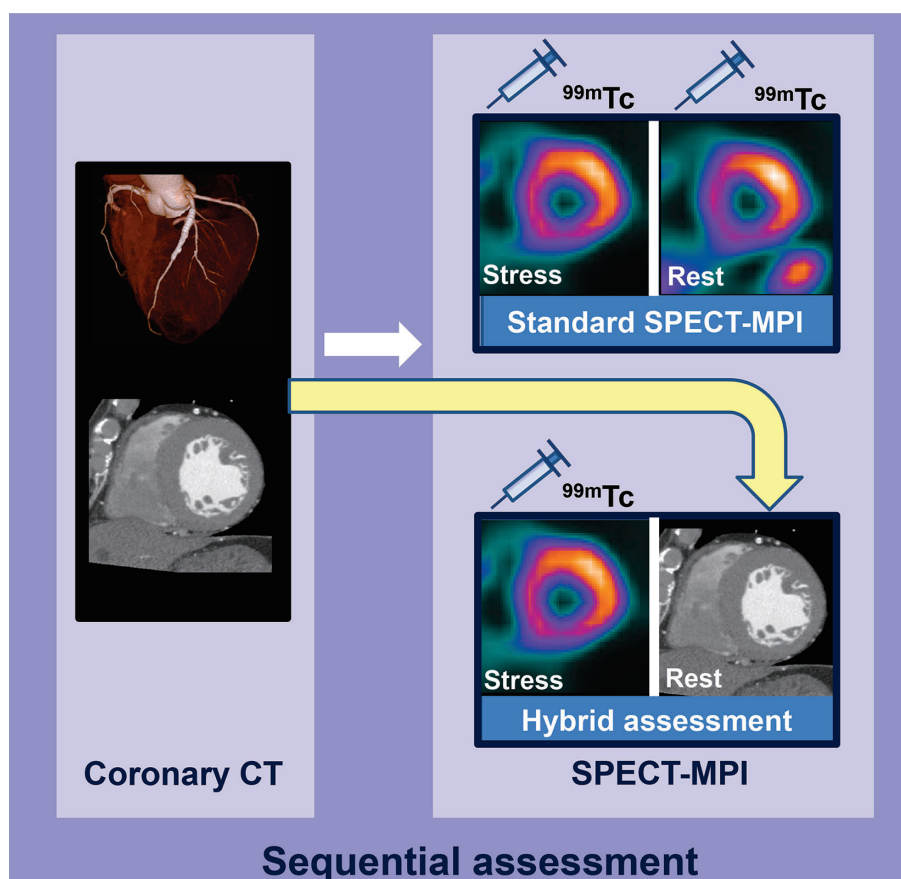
Graphical explanation of hybrid assessment using stress-only imaging as part of sequential imaging. (Right upper) Standard assessment of stress/rest SPECT-MPI, (Right lower) hybrid assessment using stress-only SPECT-MPI and CT-MPI.
